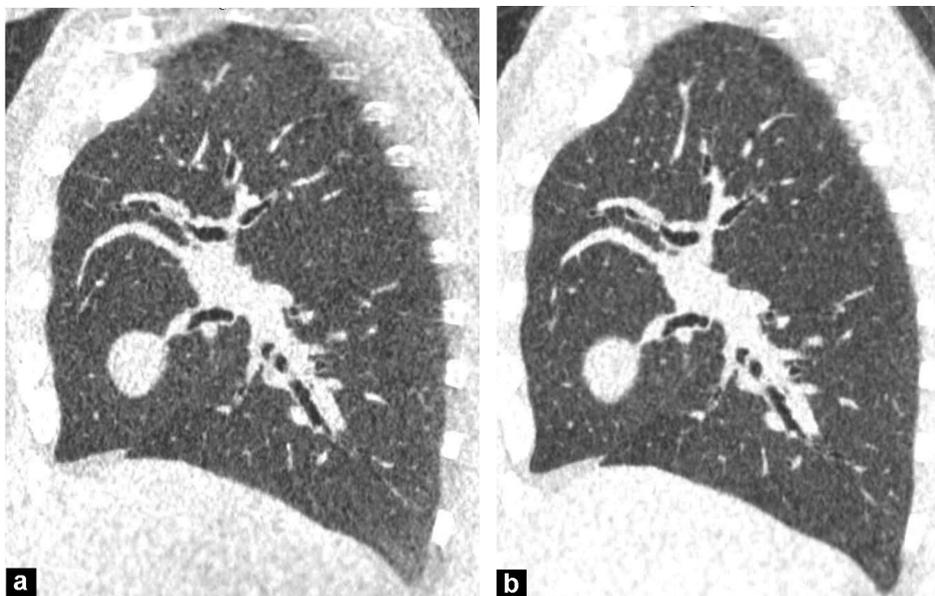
Ultra-low-dose CT image of the chest in the sagittal plane (lung window) acquired at 80 kVp (a) and at 135 kVp (b) in a 52-year-old man with a body mass index of 24.9 kg/m². The 135 kVp was rated higher by all three radiologists, with sharper margins in the apex and the base.
